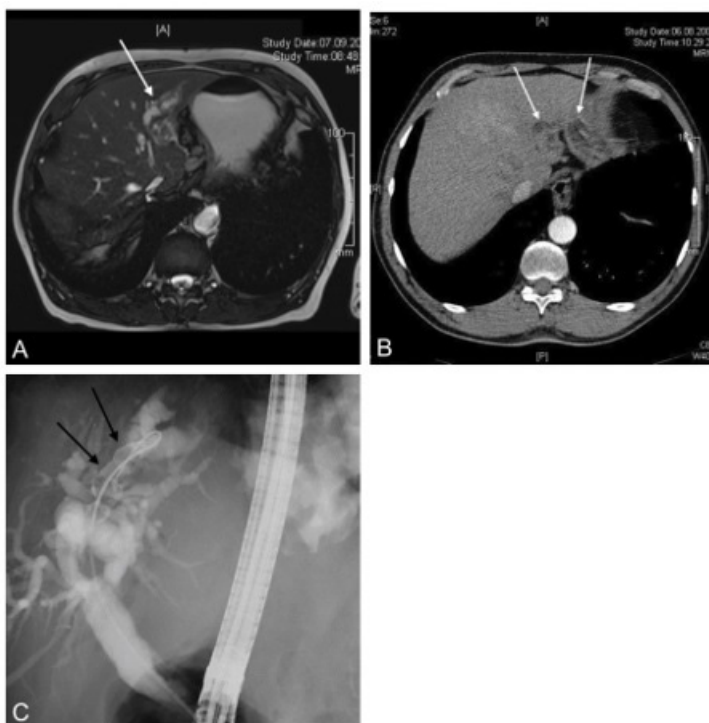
(A): MRCP scan of the patient in T2 amplification showing the intrahepatic ductal system. The left biliary system its dilated most likely in the area of the S2/S3 segment and a filling defect is visualised (arrow); 1(B): Abdominal CT-Scan (2008) with contrast medium in atrial phase with focus on the left liver. Diffuse hypodensity in segment 2 (arrows), suggesting intrahepatic cholestasis but bile duct stones cannot be detected; 1(C): Endoscopic retrograde cholangiography image of the biliary tree. It shows multiple filling defects in the S2/S3 segment (arrows) next to a guide wire with dilated ductus hepaticus communis up to 11mm in a state after cholecystectomy.
